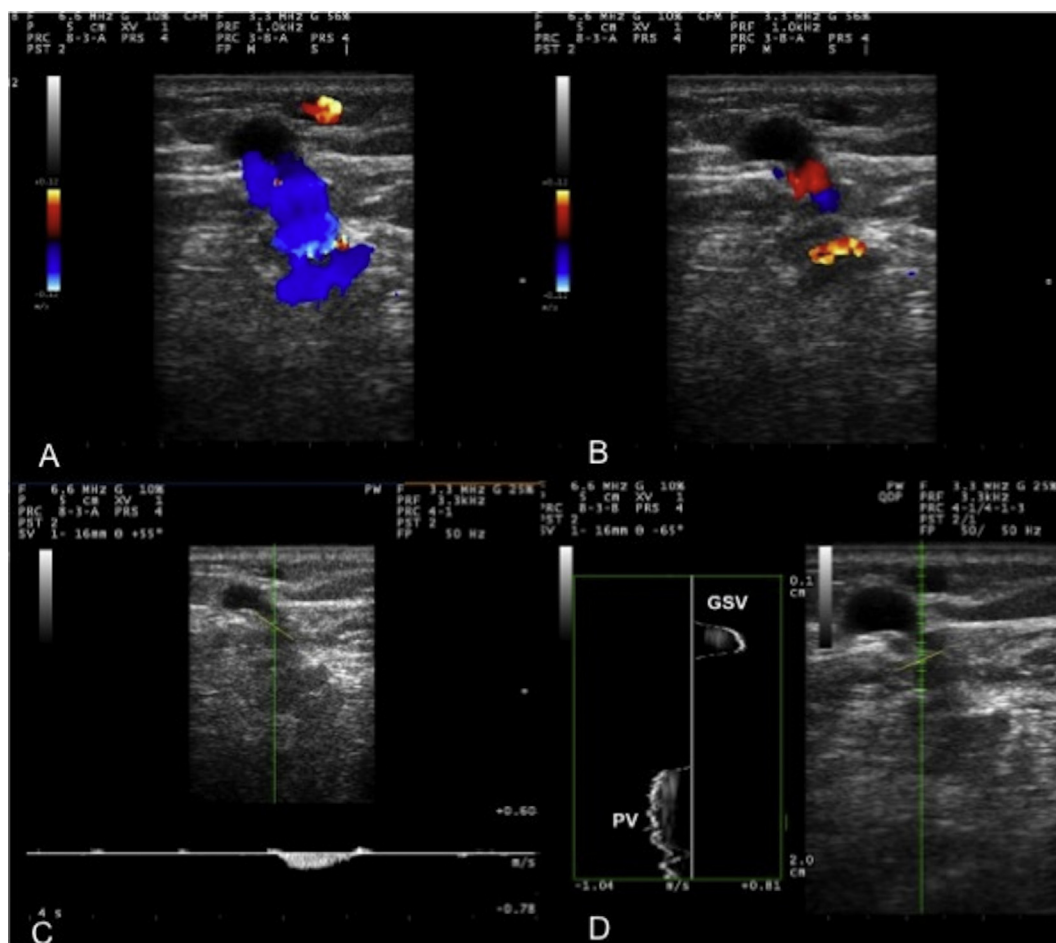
Perforating vein duplex ultrasound and quality Doppler profile (QDP) assessment: (A) Color Doppler analysis showing in blue the entire perforating vein (PV) flow moving away from the transducer and (B) in red the flow toward the transducer. (C) Pulsed wave spectral analysis reporting the flow velocities in the PV at the site of sample volume (D) Great saphenous vein (GSV) and PV net flow direction assessment by quality Doppler profile, showing the prevalent drainage direction of the entire PV. Based on the localisation of the curve on the baseline it is possible to detect a net outward (right side of the baseline) or inward (left side of the baseline) flow. The green line represents the analysis segment of 256 sample volumes involved in QDP analysis. The yellow angle is included since the software also allows extrapolation of pulsed wave (PW) analysis.
